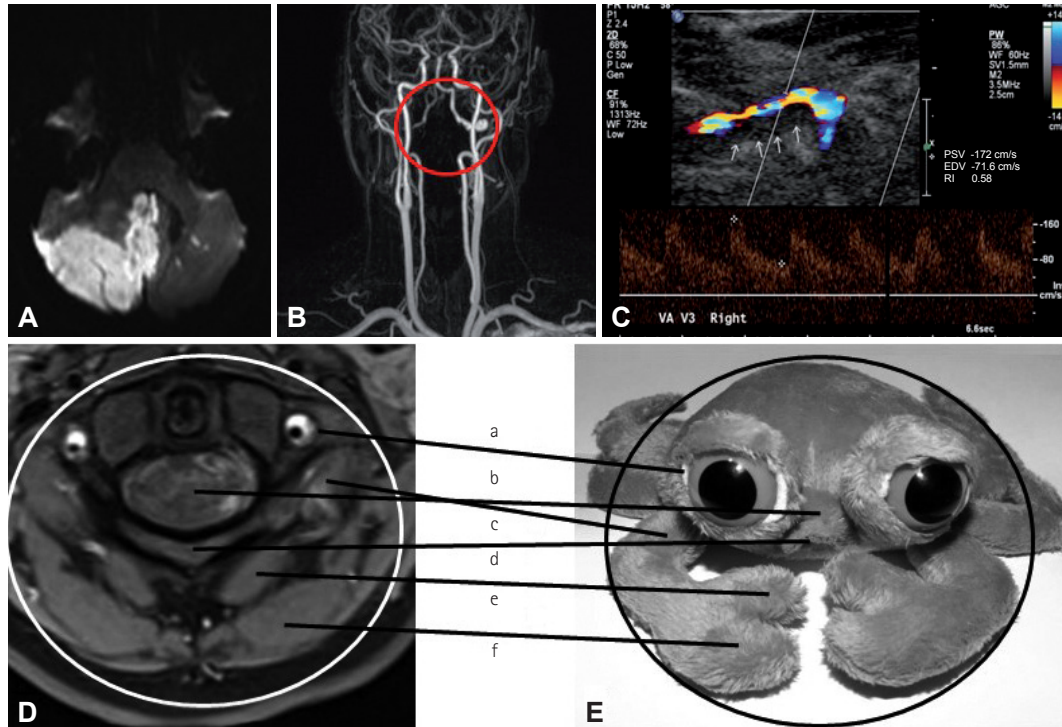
Crab sign in vertebral artery dissection. Diffusion-weighted MRI shows bilateral acute ischemic cerebellar infarction that is larger on the right side (A). Contrast-enhanced magnetic resonance angiography shows irregularities with narrowing of both distal vertebral arteries, more pronounced on the right side (B, red circle). Consistent with this, duplex sonography of the V3 segments of the vertebral arteries reveals an intramural hematoma (arrows) with luminal narrowing and consequential increase in flow velocity (PSV), which again is more pronounced on the right side (C). Axial T1-weighted fat-saturated MRI (D) confirms bilateral dissection of the distal extracranial vertebral arteries with an intramural hematoma, which strikingly resembles a crab as follows (E). a: dissected vertebral artery=eyes, b: upper cervical spinal cord=rostrum (carapace), c: obliquus capitis inferior muscle=propodus, d: posterior arch of atlas=mouth, e: rectus capitis posterior major muscle=fixed finger of cheliped, f: semispinalis capitis muscle=dactyl of cheliped. EDV: end diastolic velocity, MRI: magnetic resonance imaging, PSV: peak systolic velocity, RI: resistive index.
